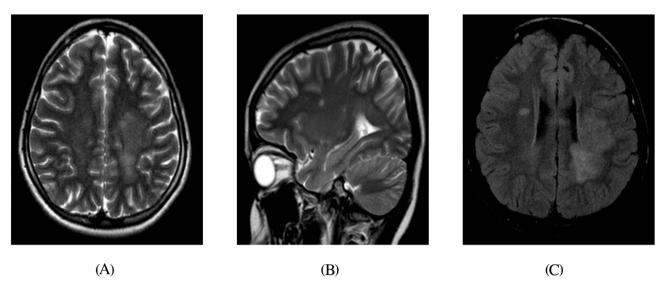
Imaging of patient with MS and NMDAR antibody: At admission, T2-weighted images revealed (A) a large confluent lesion in the left parietal area, and (B) periventricular lesions. (C) Six months later, a new lesion emerged on FLAIR sequence in the right frontocentral area.
